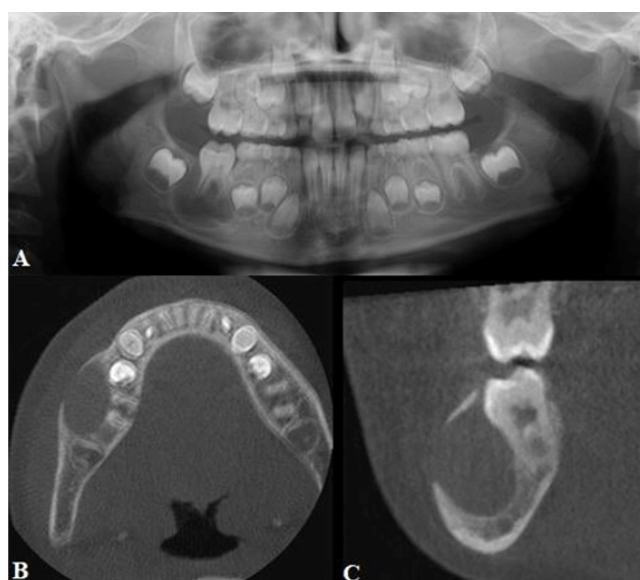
Radiographic Images of Case 2: (A) Panoramic radiography, (B) CBCT axial section, (C) CBCT coronal section.
